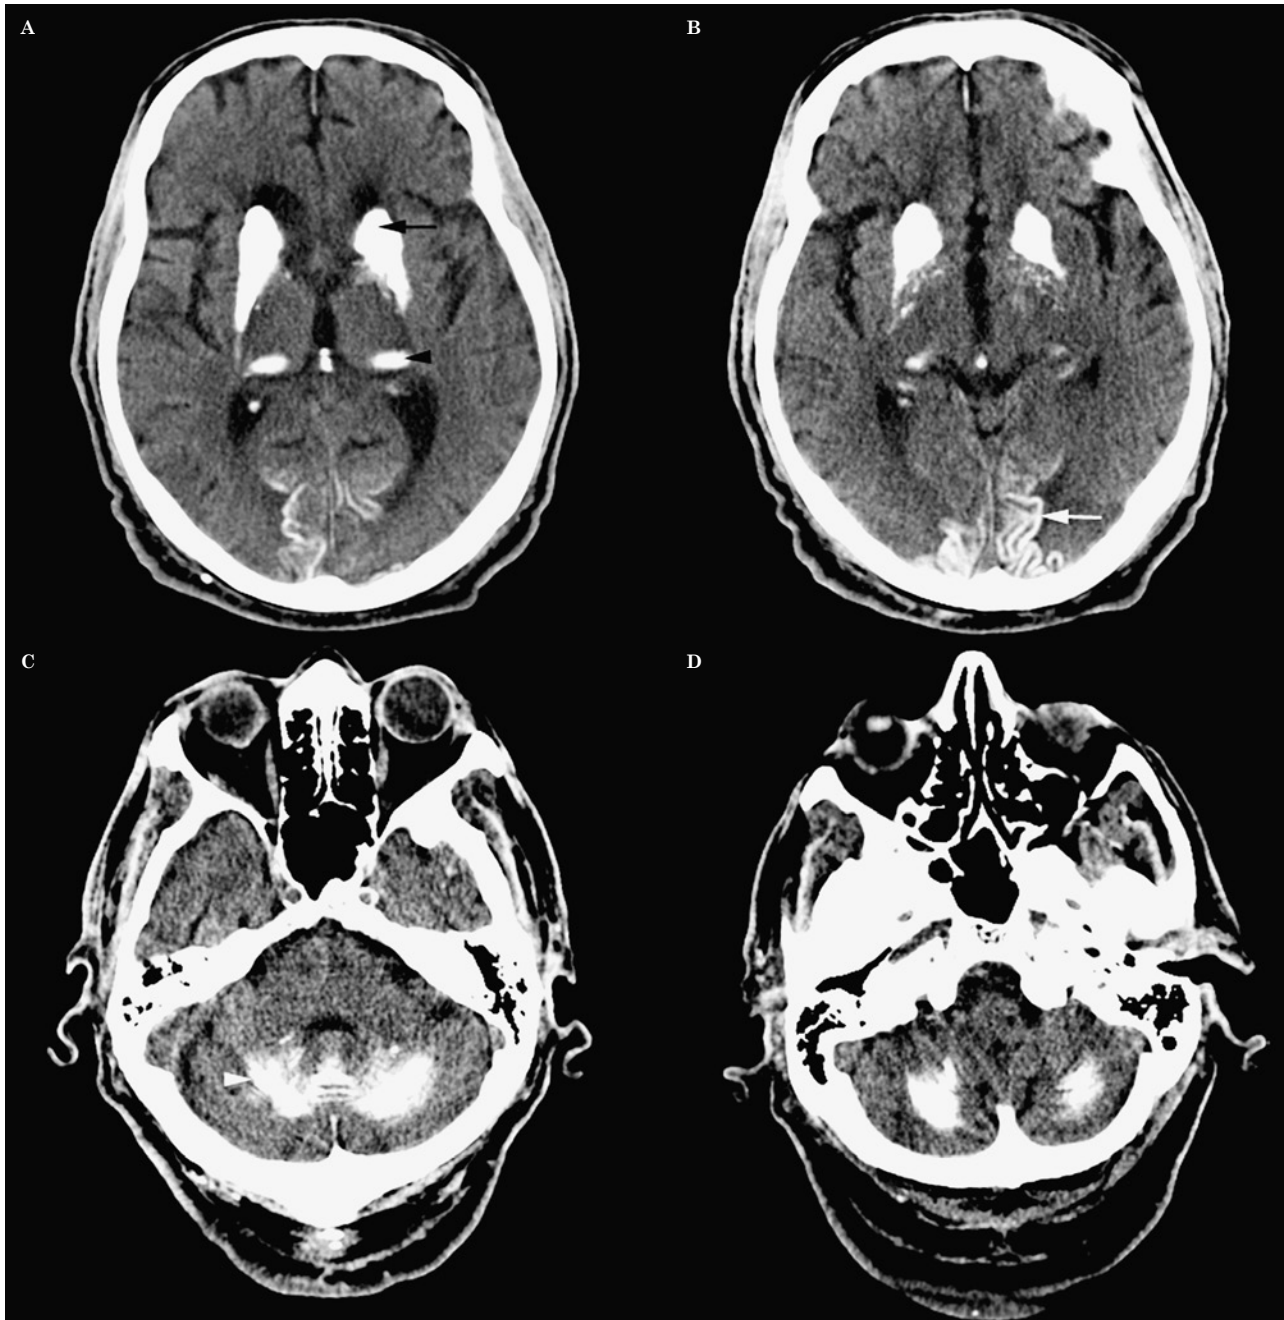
Fahr's disease. Extensive symmetric calcifications are seen in these nonenhanced CT images, in the regions of the basal ganglia (black arrow), the thalami (black arrowhead), and in the cerebellum with a particular predilection for the dentate nuclei (white arrowhead). Linear gyral calcifications are also seen in both occipital lobes (white arrow).
